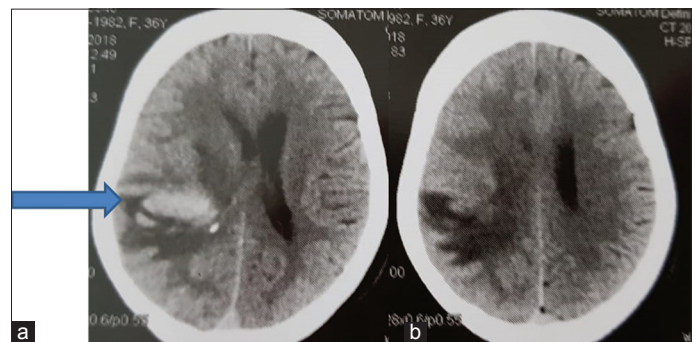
(a and b) Non-contrast computed tomography brain showing resolving bleed in the right parietal lobe with surrounding edema extending into basal ganglia and mass effect (arrow)
